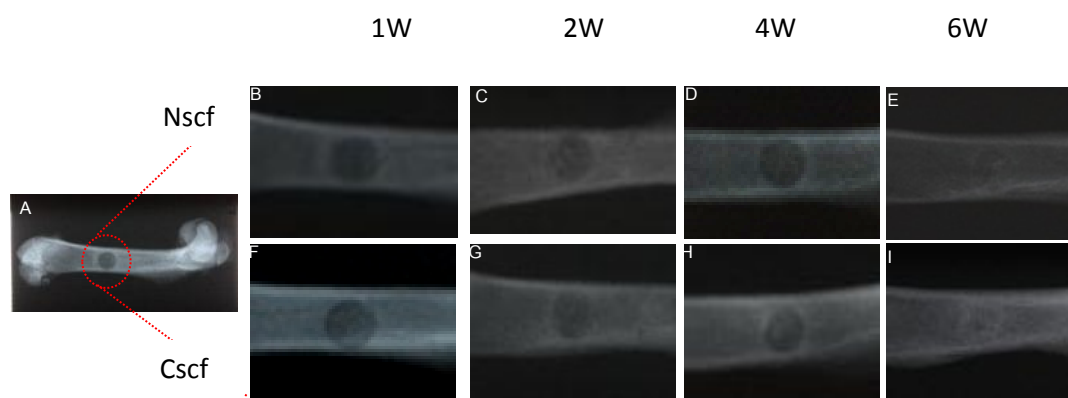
X-ray films of circular defects in femoral bone (A) post operation 1(B and F), 2(C and G), 4(D and H) and 6(E and I) weeks. The x-ray examination showed no different explicitly between non-coated (B, C and D) and coated scaffolds (E, F and G) at 1 to 4 weeks. The density of new bone formation within scaffold dramatically increased from the 1st to 4th week and revealed the high density of bone formation at the 6th week in coated scaffold implantation.
